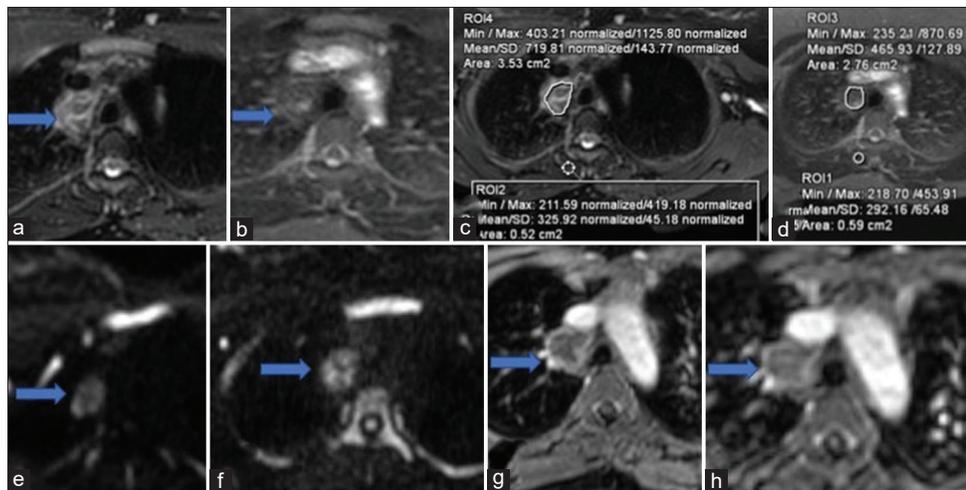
A case of tuberculous mediastinal lymphadenopathy in a 28-year-old female. Interval between first magnetic resonance imaging (a, c, e, and g) and second magnetic resonance imaging (b, d, f, and h) was 6 months. Right paratracheal lymph node was hypointense and T2 signal intensity ratio was decreased in follow-up magnetic resonance imaging (a, b, c, and d). However, diffusion restriction and thin rim of peripheral enhancement was still present in the follow-up magnetic resonance imaging (e, f, g, and h)
